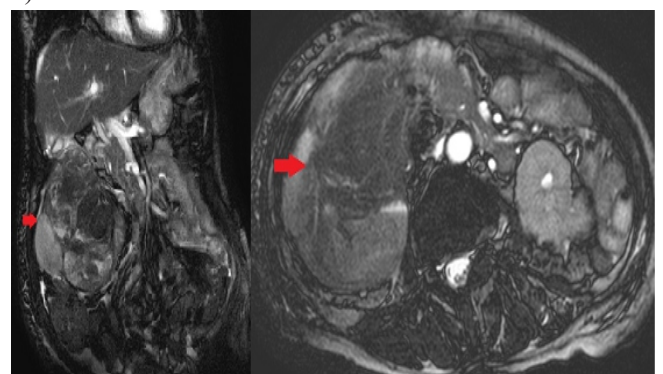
MRI showing right renal mass lesion (red arrow) in coronal and axial view
